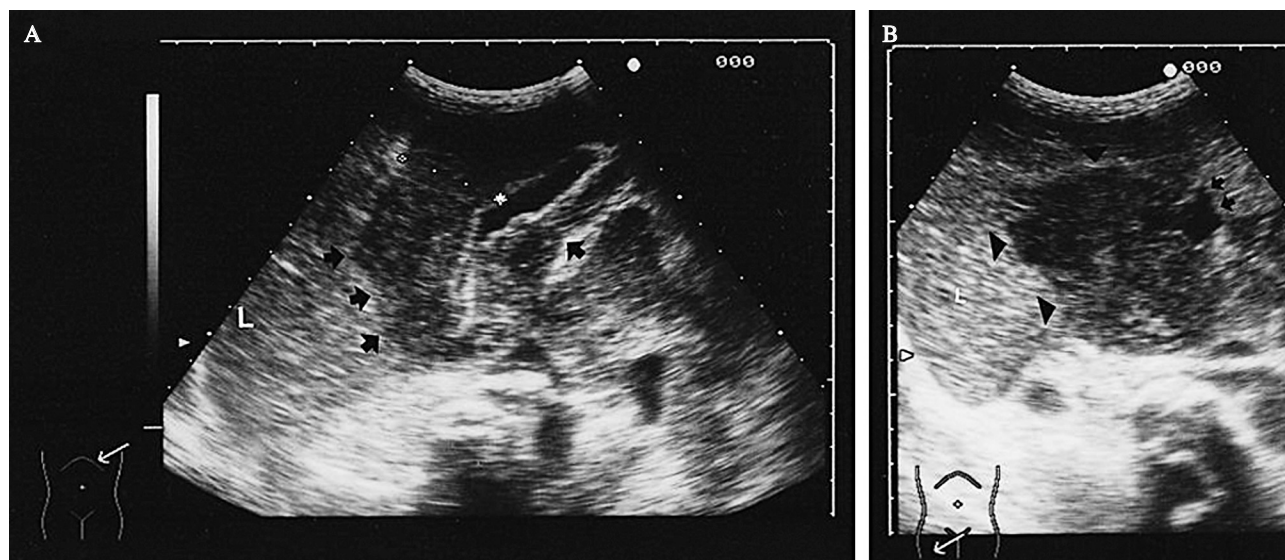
A: Longitudinal section of the gallbladder. Prominent hypoechoic gallbladder wall thickening is seen (arrows). Asterisks (+) indicate the inner surface of the gallbladder. L: Liver. B: Transverse sonogram showing asymmetrical gallbladder wall thickening (arrowheads) (arrows: gallbladder lumen).
